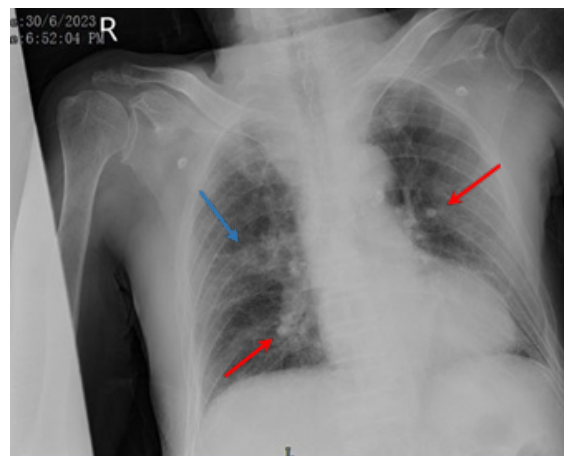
Chest x-ray showed opacities seen over right upper, middle and lower zones. Rounded opacities projected over bilateral perihilar and mediastinum region with some of it calcified (Red arrow). Cavitation over right middle zone (Blue arrow)
